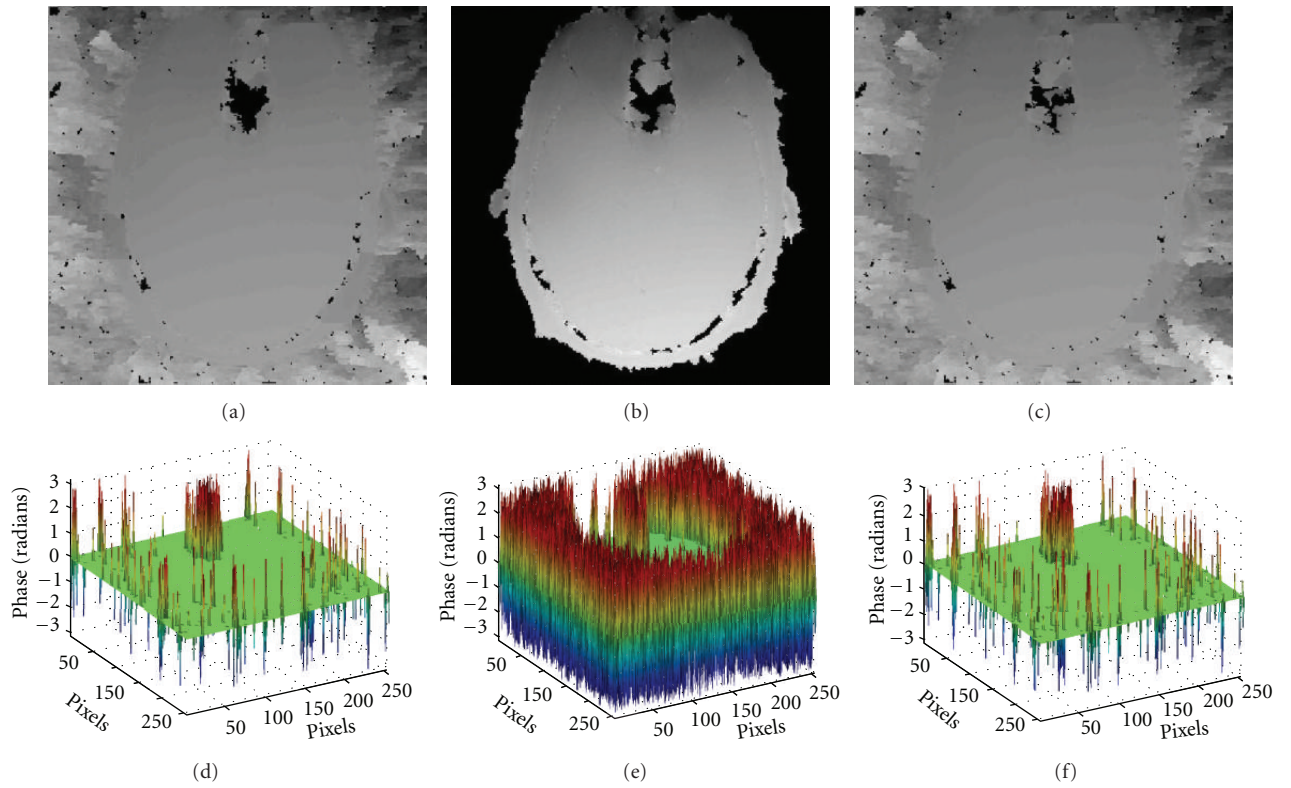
The top row is the unwrapped phase image for the MRI head phase image in Figure 6(a) achieved by (a) dPSO, (b) Goldstein's, and (c) MCM algorithms. The bottom is the corresponding difference map got by (d) dPSO, (e) Goldstein's, and (f) MCM algorithms.
